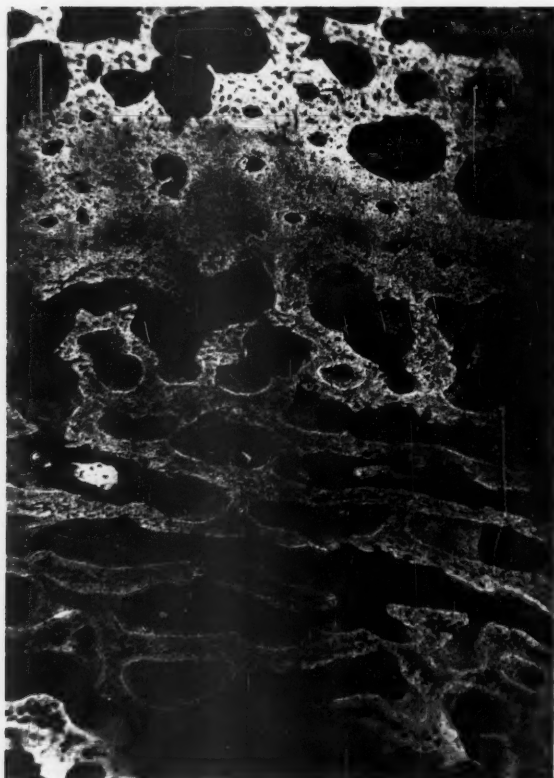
Cross section (100 micra) of the outer part of the tibia from a case of osteopetrosis microphotographed with 25 KV X-rays showing the distribution of mineral salts.
